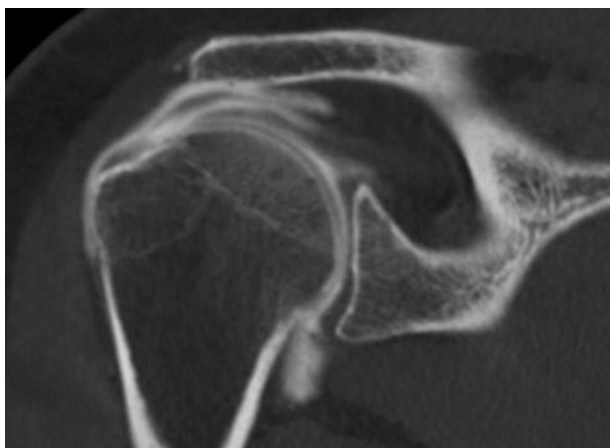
Arthro—computed tomography scan in a right shoulder (coronal view), showing a delaminated posterosuperior cuff tear.
